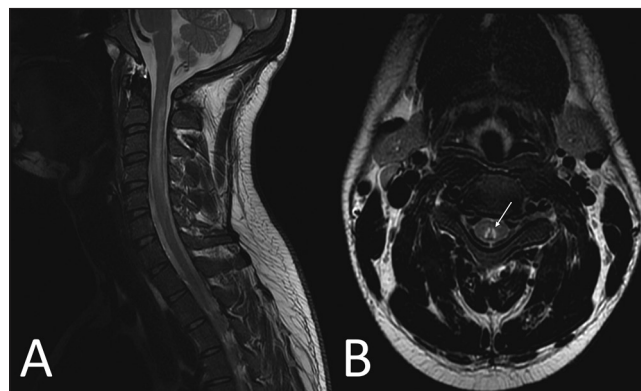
MRI of a patient presenting with subacute combined degeneration secondary to vitamin B12 deficiency depicts hyperintensity involving the posterior part of the cervical spinal cord on T2-W sagittal (A) image and inverted "V" sign on T2-W axial section (B, arrow)
